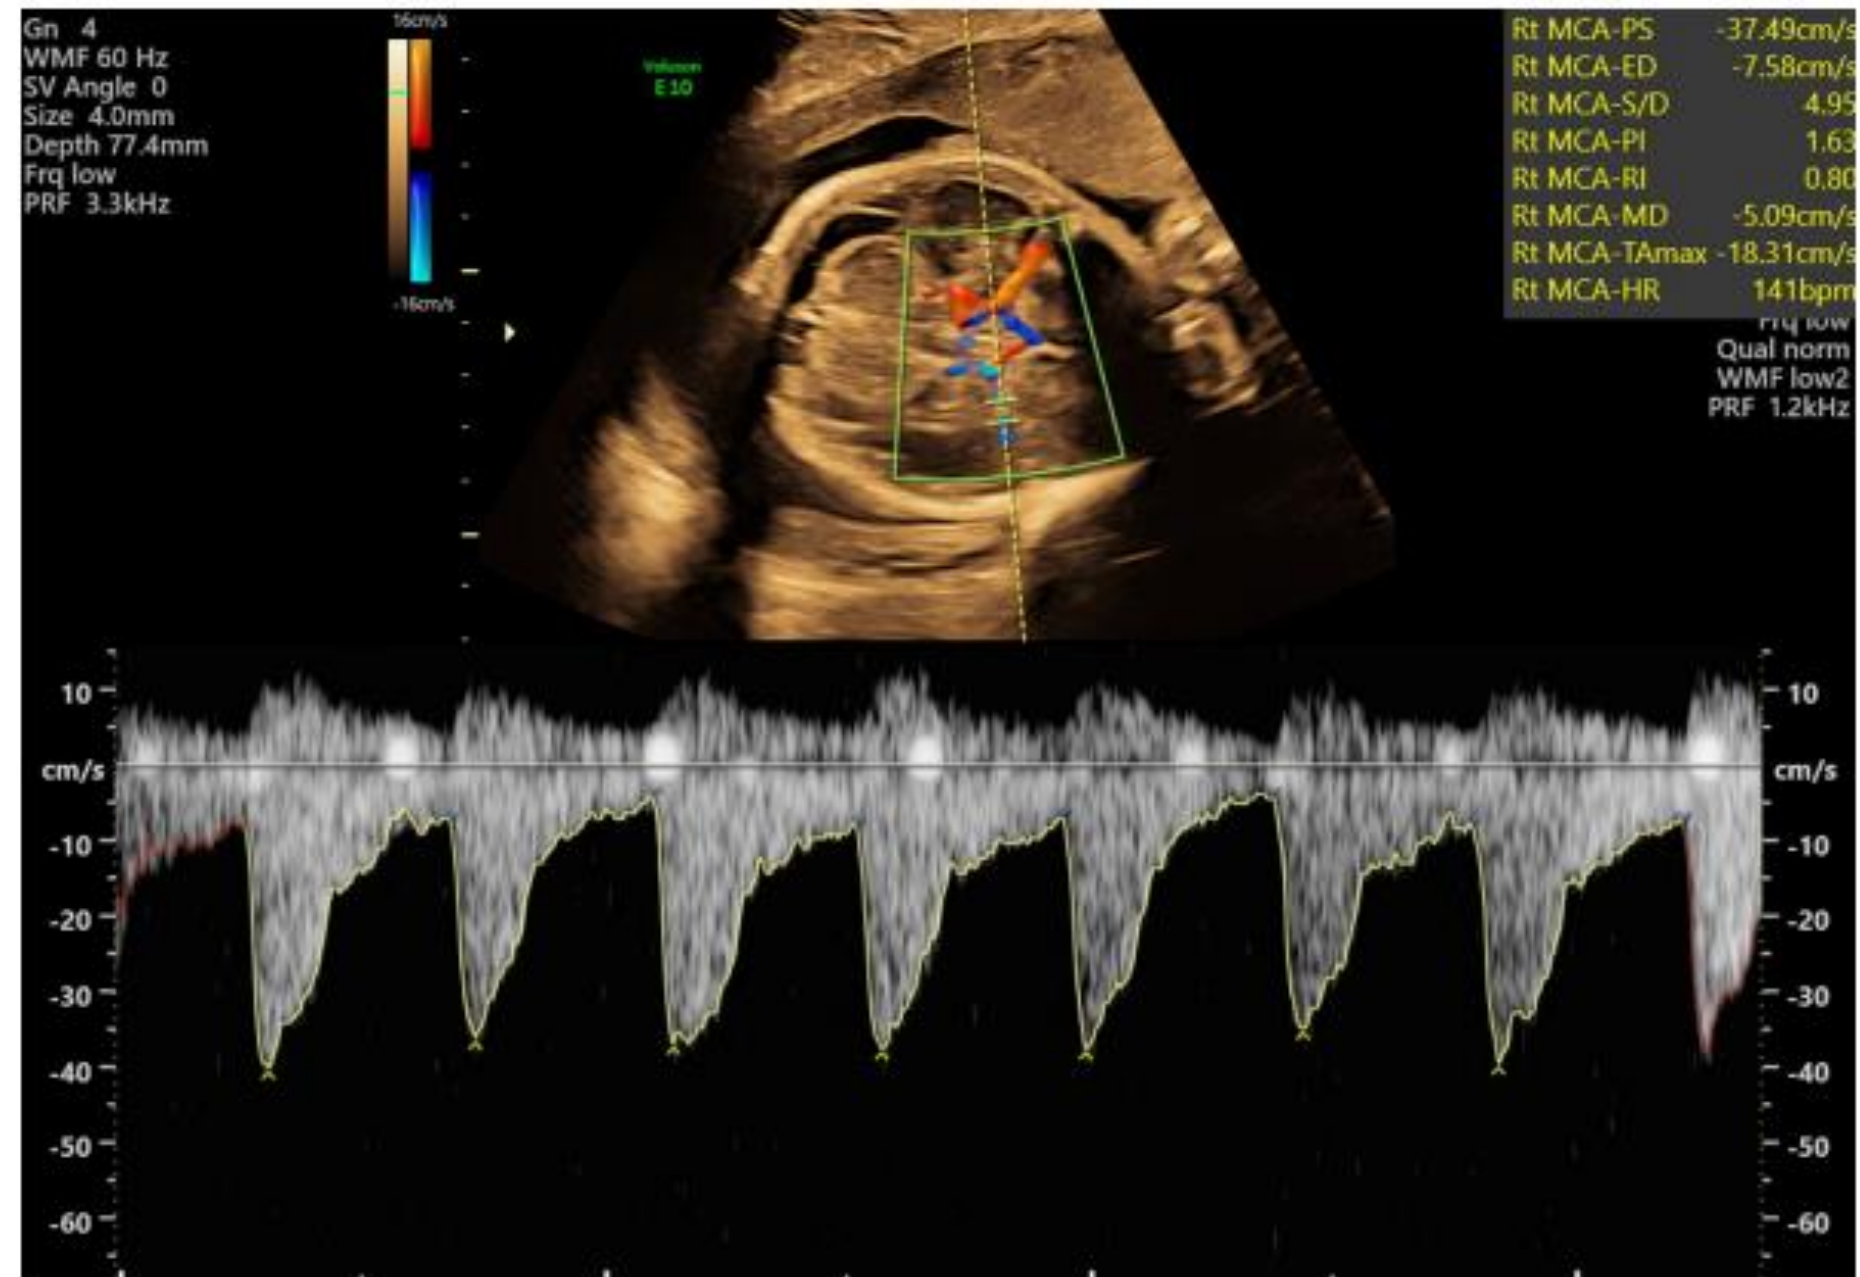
Middle cerebral artery (MCA) Doppler waveforms obtained from the far-field MCA. Note the 0° angle of insonation.
